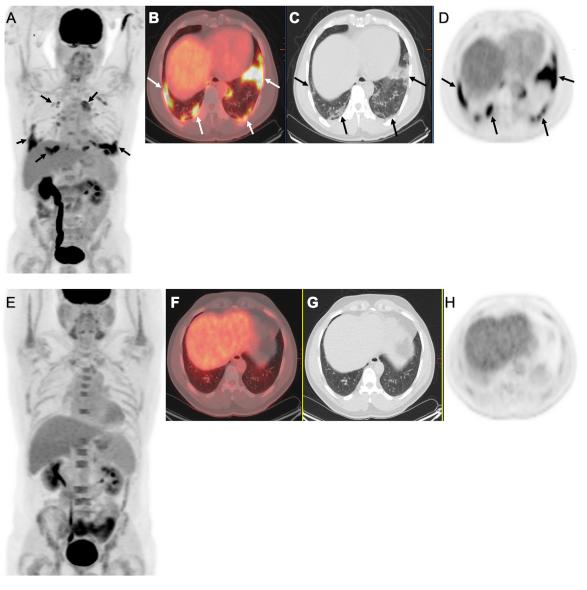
62-year-old male patient with history of lymphoma underwent PET/CT scan for restaging. PET maximum intensity projection (MIP) images (A,D) and axial PET/CT fusion images (B) shows hypermetabolic bilateral predominantly subpleural areas (arrows) with the highest SUV max of 8.7, corresponding to ground glass opacities and solid consolidations on the axial low dose CT scan. PET maximum intensity projection (MIP) images (E,H) and axial PET/CT fusion images (F) on 3 month follow-up PET/CT showed complete resolution of bilateral hypermetabolic ground glass opacities and solid consolidations.
